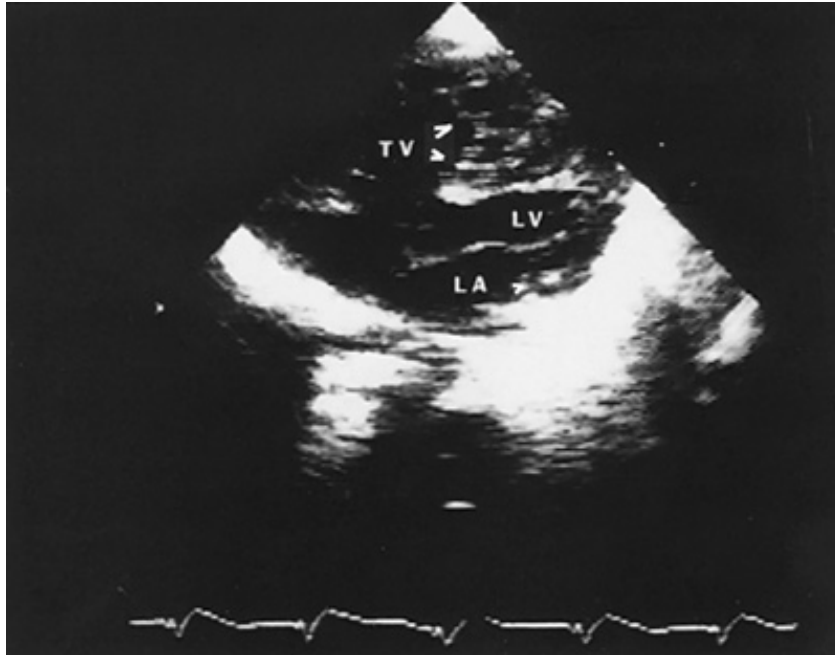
Two-dimensional echocardiogram in parasternal view in a patient with Ebstein's anomaly of the tricuspid valve (TV). Numerous attachments of the tricuspid valve (*arrowheads*) to the interventricular septum and right ventricular apex are seen. LV = left ventricle; LA = left atrium.
